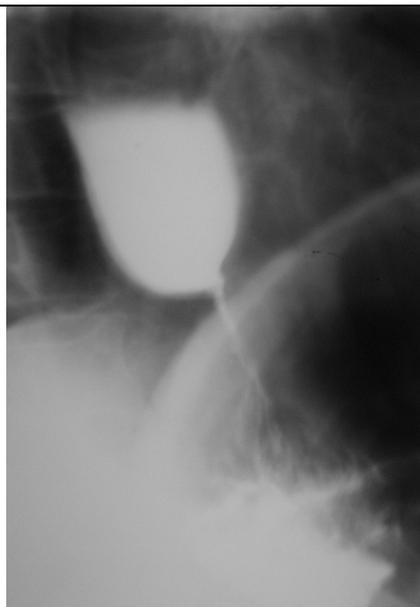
Radiograph of lower thoracic and abdominal departments of an esophagus (single contrast). Symmetric cone-shaped narrowing of abdominal department of esophagus with symmetric smooth contours, supra-stenotic enlargement is marked. Achalasia of esophagus.
